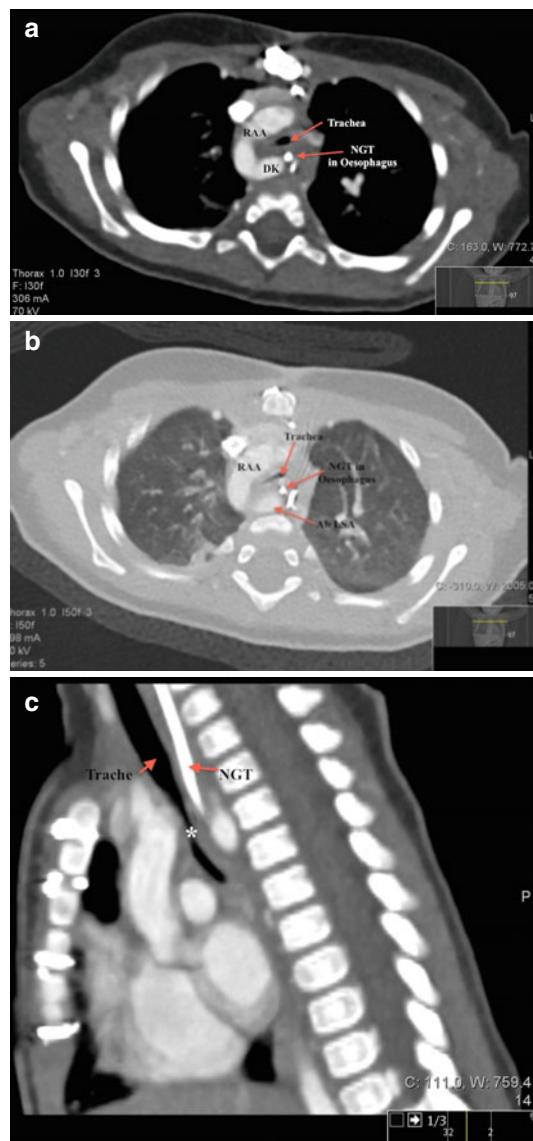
(a) Axial image from the patient's CT angiogram on a mediastinal window showing right aortic arch (RAA) with diverticulum of Kommerell (DK) and NGT inside the oesophagus. Significant compression of the trachea can be seen. (b) Axial image from the patient's CT angiogram on a lung window showing the right aortic arch (RAA) and aberrant left subclavian artery (Ab LSA) compressing on the trachea and oesophagus. The trachea is severely narrowed. (c) Sagittal view of the patient's CT angiogram showed that the trachea and oesophagus are compressed by the vascular ring causing severe narrowing (*). (d) 3D reconstruction of the CT angiogram from the posterior aspect to show the aberrant left subclavian artery (Ab LSA) and right aortic arch impinging on the oesophagus and trachea (oesophagus and trachea not shown; nasogastric tube (NGT) indicates position of oesophagus)
